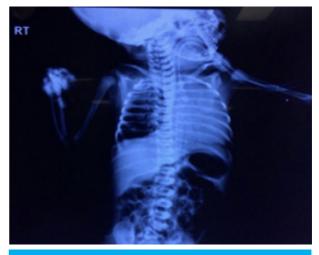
Preoperative Chest X-Ray (Endotracheal tube in situ).
